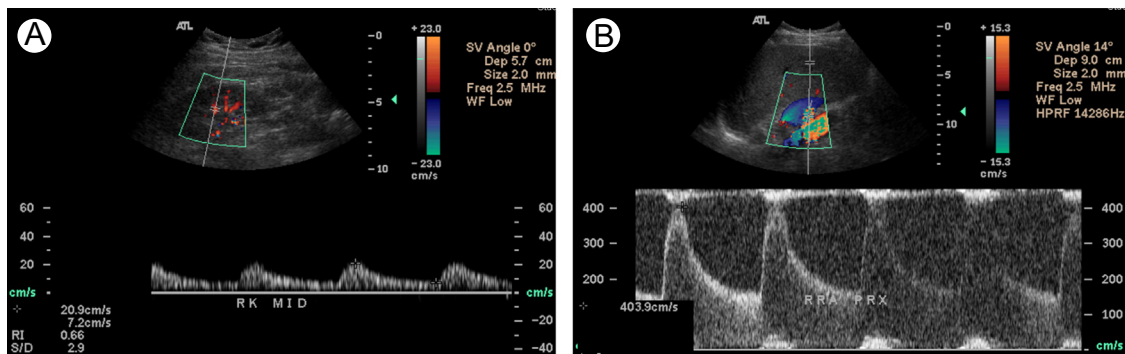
Renal duplex ultrasonography in this patient with right renal artery stenosis demonstrating (A) parvus-tardus waveforms in the intraparenchymal renal artery branches and (B) an elevated peak systolic velocity. (Color version of figure is available online.)
